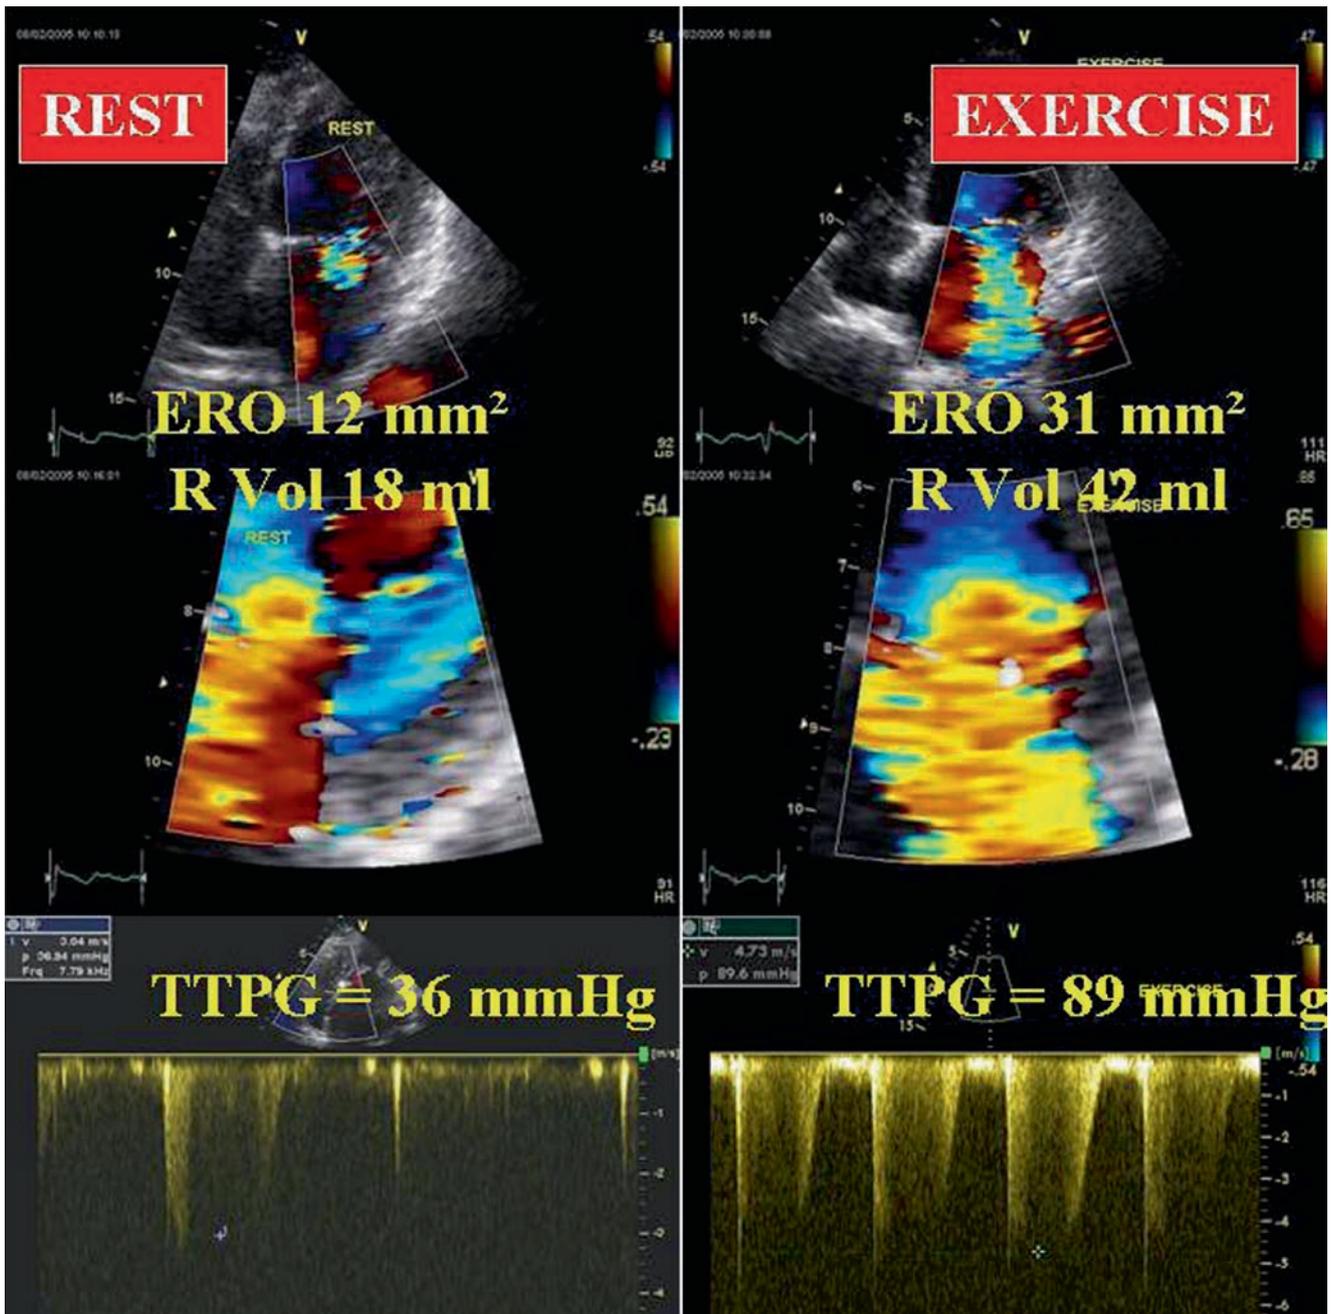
Apical 4-chamber view showing colour flow Doppler and proximal flow convergence region at rest and during exercise in a patient with a large exercise-induced increase in mitral regurgitation
